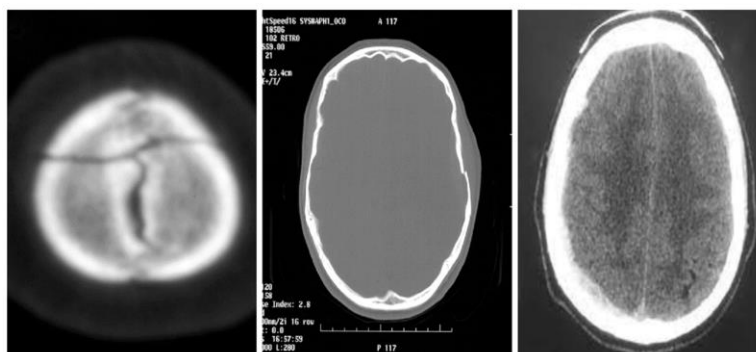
(a) CT image showing a linear oblique fracture involving the bilateral parietal bones. (b) Fracture of overlying bone visualized on the bone window. (c) CT scan brain shows a small hyperdense subdural hematoma along the right cerebral convexity.
